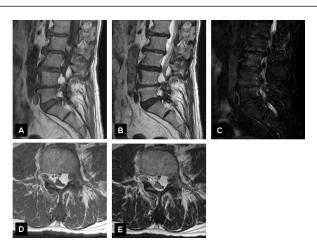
MRI showing deformation of the dural sac compressed by an excessive deposition of epidural fat tissue. A: Sagittal T1weighted images. B: Sagittal T2-weighted images. C: Sagittal fat suppressed T2-weighted images. D: Axial T1-weighted images at the L4 level. E: Axial T2-weighted images at the L4 level
